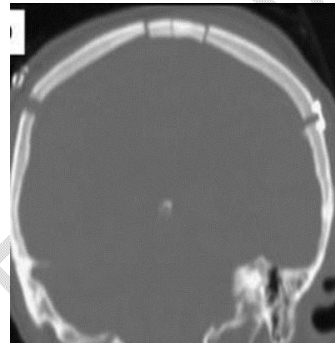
CT bone window, coronal cut, showing the biparietal bony craniotomy with the central bony strip in place.
